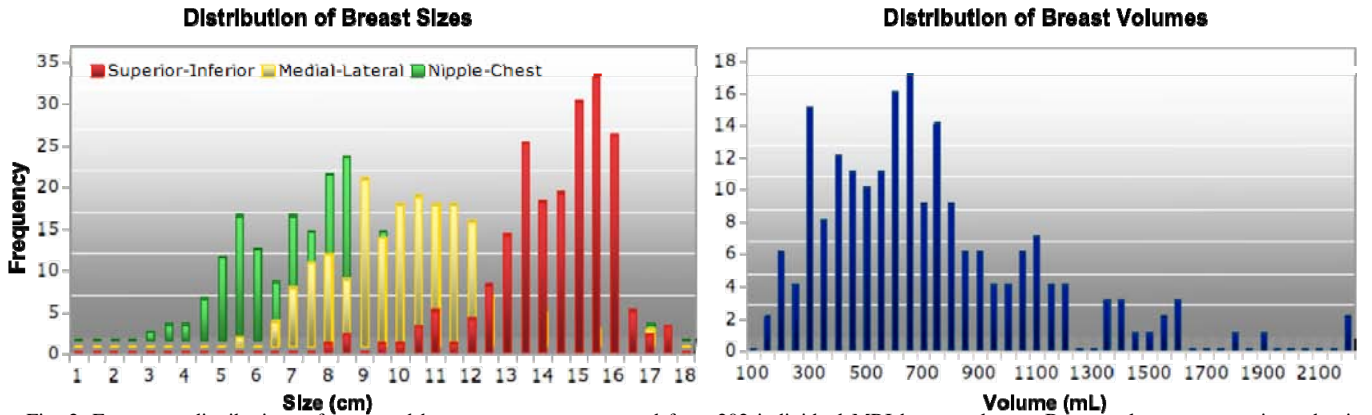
Frequency distributions of measured breast parameters extracted from 202 individual MRI breast volumes. Breast volumes were estimated using segmentation and mesh volume calculations.
